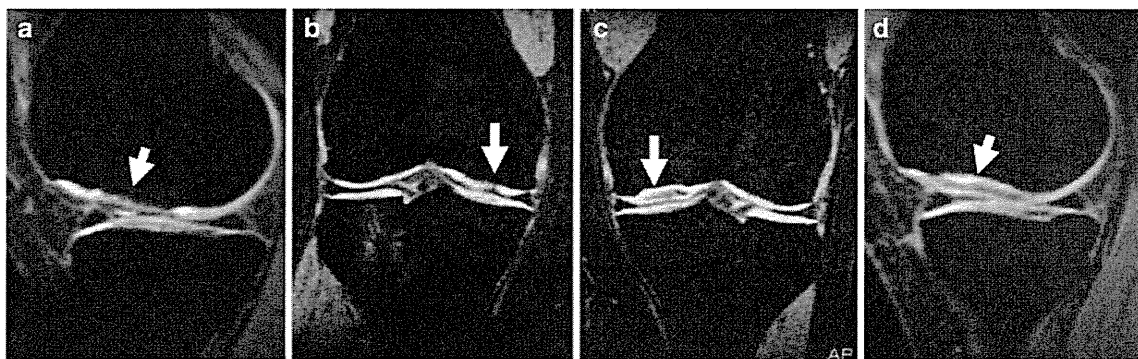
T1-weighted magnetic resonance imaging (MRI) with fat suppression showed an irregular joint surface corresponding to the articular cartilage of the bilateral medial femoral condyle (*arrows*).
